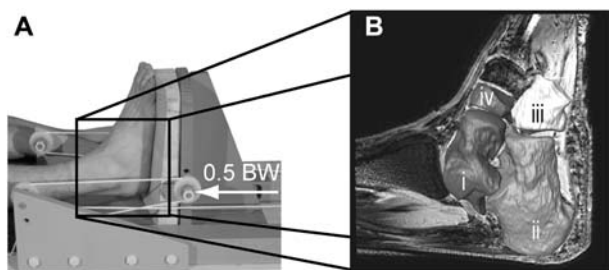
(A) Foot positioning and loading device of the MR imaging procedure. A load of half bodyweight was applied axially under the heel. (B) MR image with 3D reconstructed tarsal bones: (i) talus, (ii) calcaneus, (iii) cuboid, and (iv) navicular.
